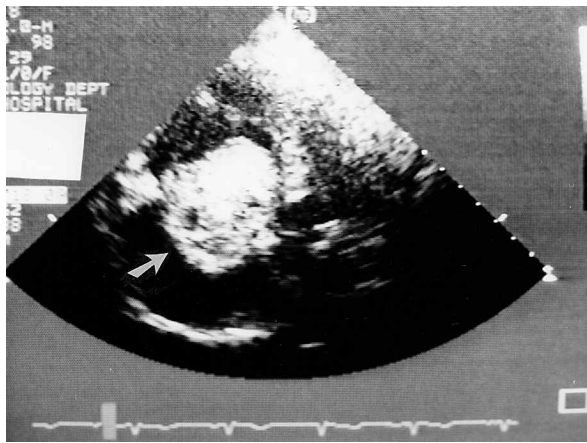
Echocardiogram (M-mode) shows the tumor (arrow) prolapsing through the tricuspid valve.
